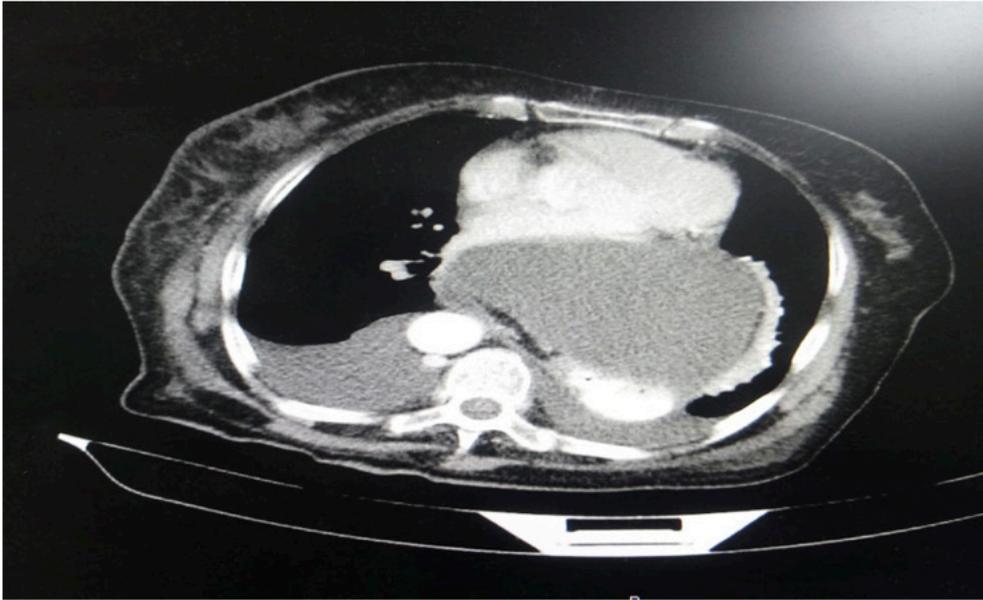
Thorax computed tomography represents a hiatus hernia that compressing the heart.
